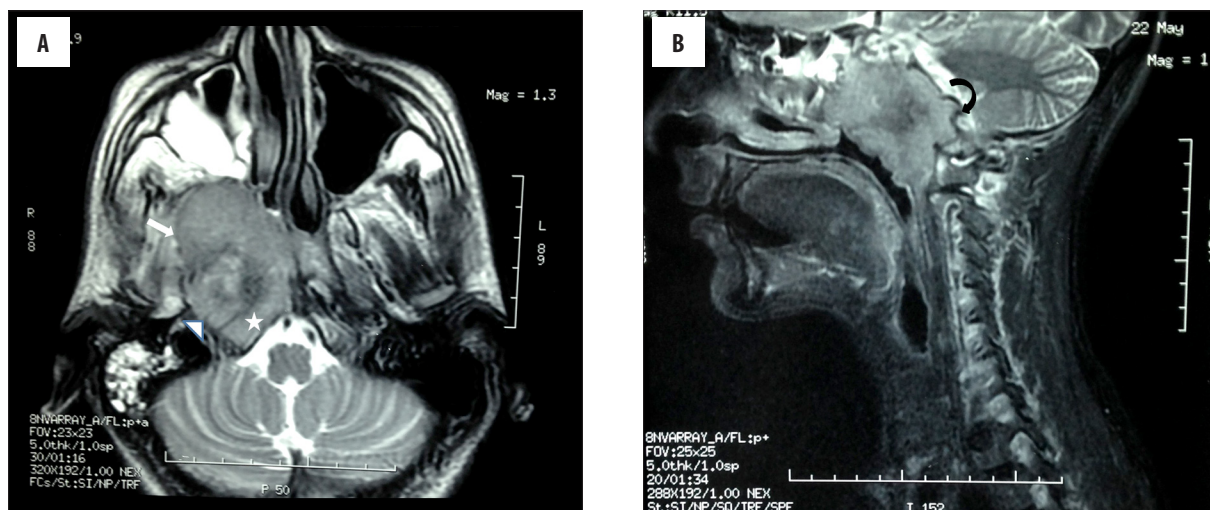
(A) A 17-year-old boy with an asymmetric nasopharynx mass which extends to the right parapharyngeal (arrow head) and masticator area (arrow) and which involves the right half of the clivus (star) (case 1) and which is monitored in the hyperintense signal characteristics on T2-weighted images compared to the muscle. (B) Extension of the mass to the nasal cavity and oropharynx posterior wall in sagittal T2-weighted images with clivus destruction is (arrow).
